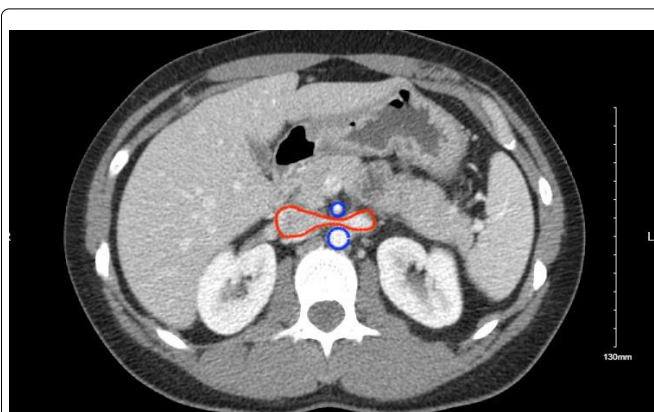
Patient's CT scan showing the proximal superior mesenteric artery (SMA) off the aorta, both highlighted in blue. The distal SMA compressed the left renal vein, highlighted in red. The marked narrowing of the left renal vein is characteristic of nutcracker syndrome.
